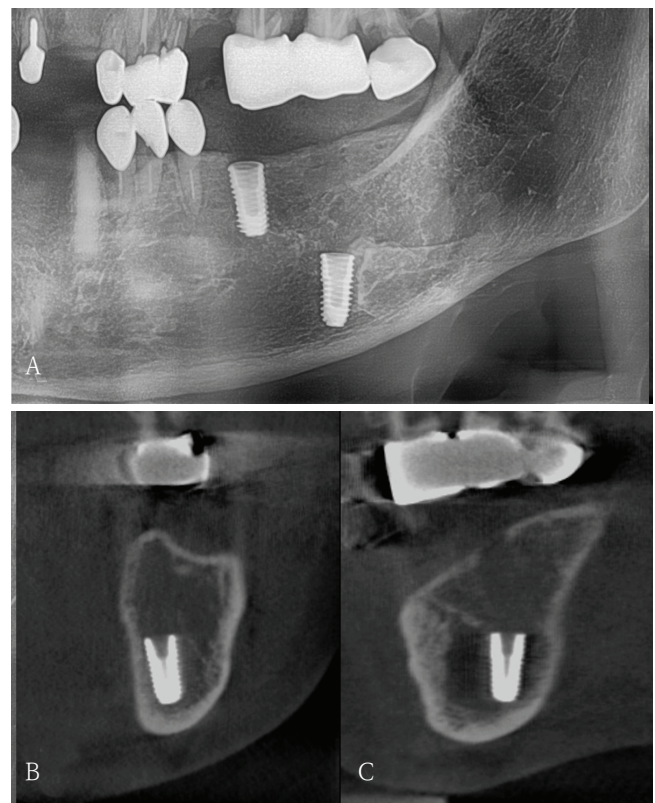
A. Panoramic radiograph obtained at the first visit shows a displaced implant fixture in the left mandibular first molar region. Coronal (B) and sagittal (C) cone-beam computed tomography images demonstrate the fixture positioned lingual to the inferior border of the mandible. An ill-defined radiolucent lesion with reduced trabecular density is observed in the edentulous posterior mandible without cortical expansion.
